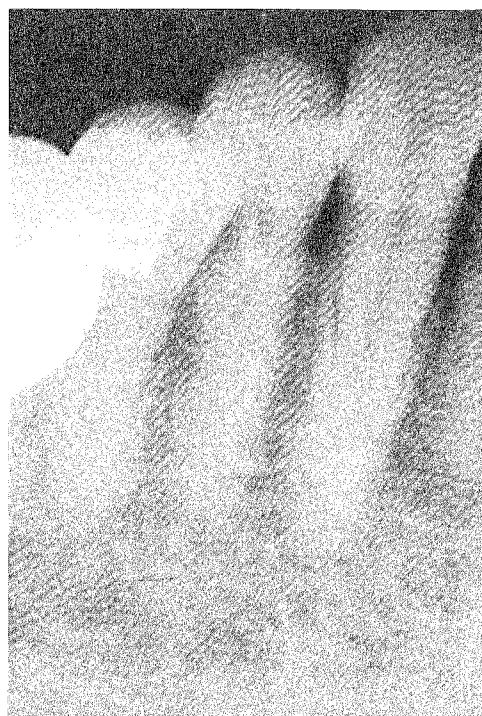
Periapical radiograph of the affected area. Alveolar crest height was close to the cemento-enamel junction, and no evidence of pulp or periapical pathosis or periodontal disease was apparent.
